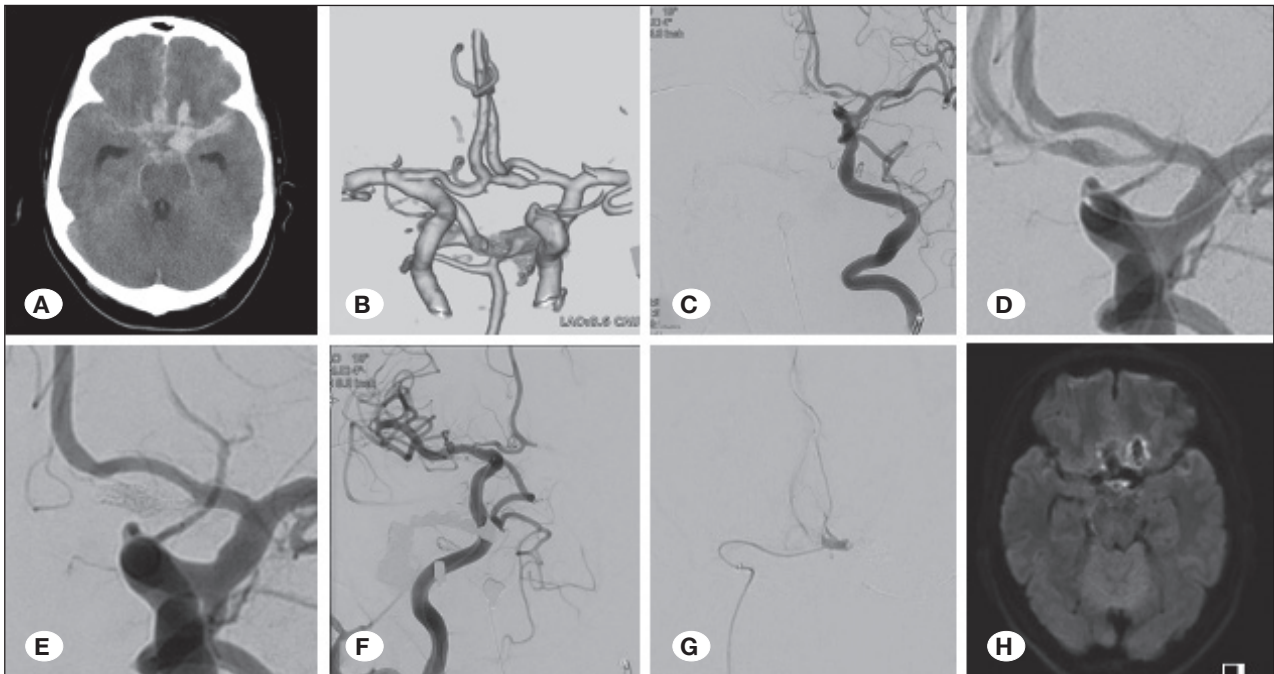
Endovascular trapping in Case 1. A) Initial CT shows a diffuse SAH with intracerebral hemorrhage in the left frontal lobe. B) CT angiography reveals a dissecting aneurysm in the fenestrated left A1 segment. C, D) Anteroposterior view of the left ICAG before endovascular surgery depicts a dissecting aneurysm in the fenestrated left A1 segment. E, F) The anteroposterior view of the left and right ICAG displays complete internal trapping of the left A1 dissecting aneurysm while preserving the antegrade left ACA blood flow via the unaffected left fenestrated A1. G) Anteroposterior view of the Acom segment angiography using a microcatheter during the internal trapping reveals the patency of the hypothalamic artery. H) Diffusion-weighted image on postoperative day 1 discloses no new ischemic lesions in the territory of the ACA.
